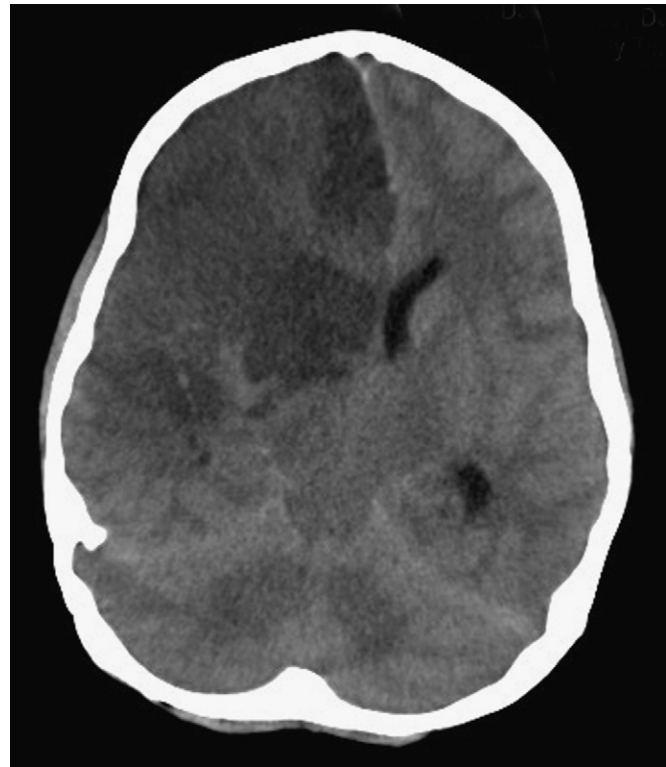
Cranial CT without contrast in a 9-year-old with acute onset of left-sided weakness, demonstrating extensive edema with midline shift in the right cerebral hemisphere, consistent with infarctions in the right anterior cerebral and middle cerebral artery distribution, sulcal effacement, and compression of the right lateral and third ventricle. This patient was still awake and following commands when this scan was obtained.
